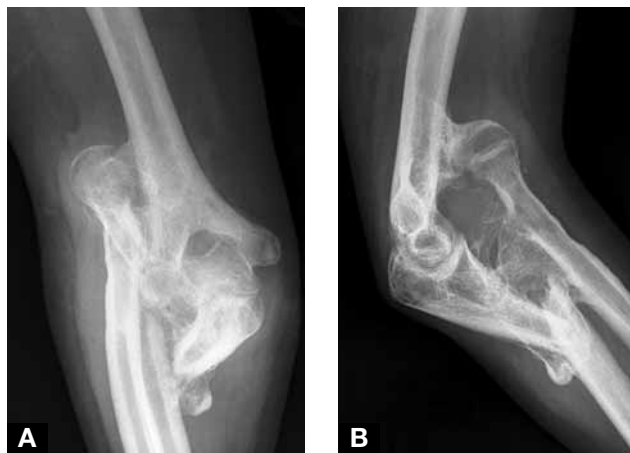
(A) Anteroposterior and (B) lateral radiographs at presentation show patient's chronic type 1 Monteggia fracture with 30° angulated ulnar malunion and proximal radioulnar synostosis.
